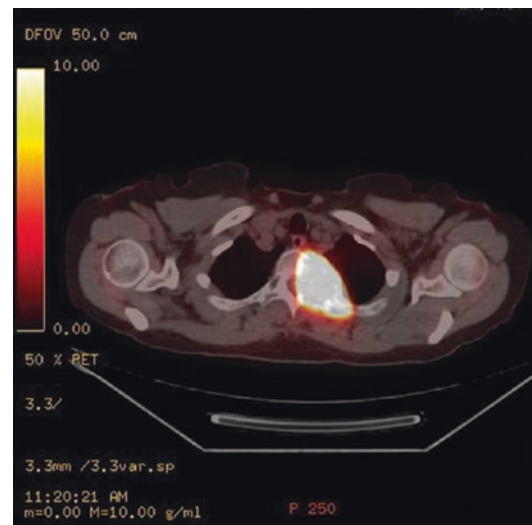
Combined PET/CT image revealing thoracic vertebral and paraspinal muscle metastases in a patient with widely metastatic Hürthle cell carcinoma, represented by intense focal FDG uptake in T2, T3, and the surrounding soft tissue
